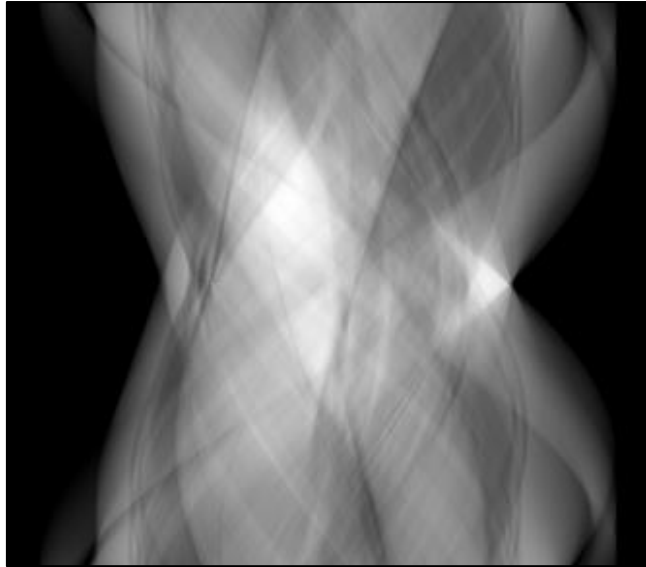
A sinogram of the activity map of frame 28 obtained during the forward projection step using the Discovery PET/CT 710 scanner model.
